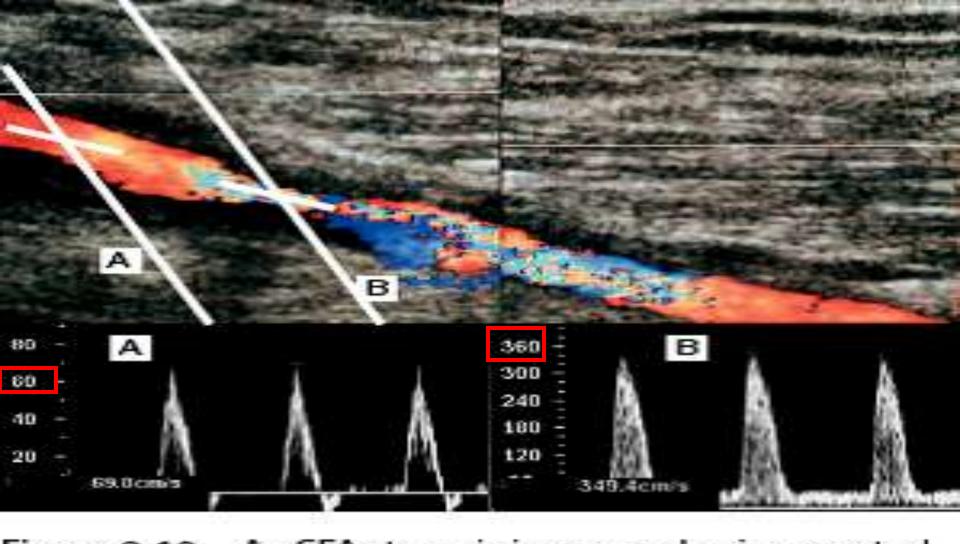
An SFA stenosis is assessed using spectral Doppler. A: Measurement of the peak systolic velocity just proximal to the stenosis. B: Measurement of the peak systolic velocity across the stenosis. The peak systolic velocity ratio is calculated by dividing B by A, producing a velocity ratio of 5. This would indicate a severe stenosis.
